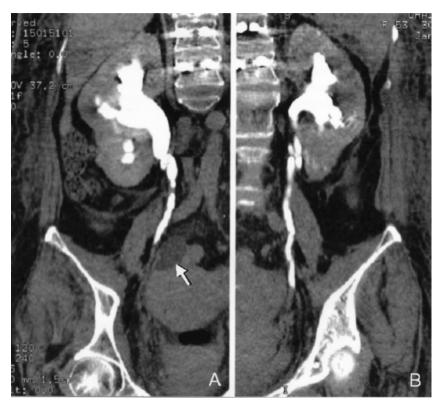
Computed tomography: hydroureteronephrosis noted at the mid-third of the right ureter (A) and the lower third of the left ureter (B). Arrow: ovarian cyst.
